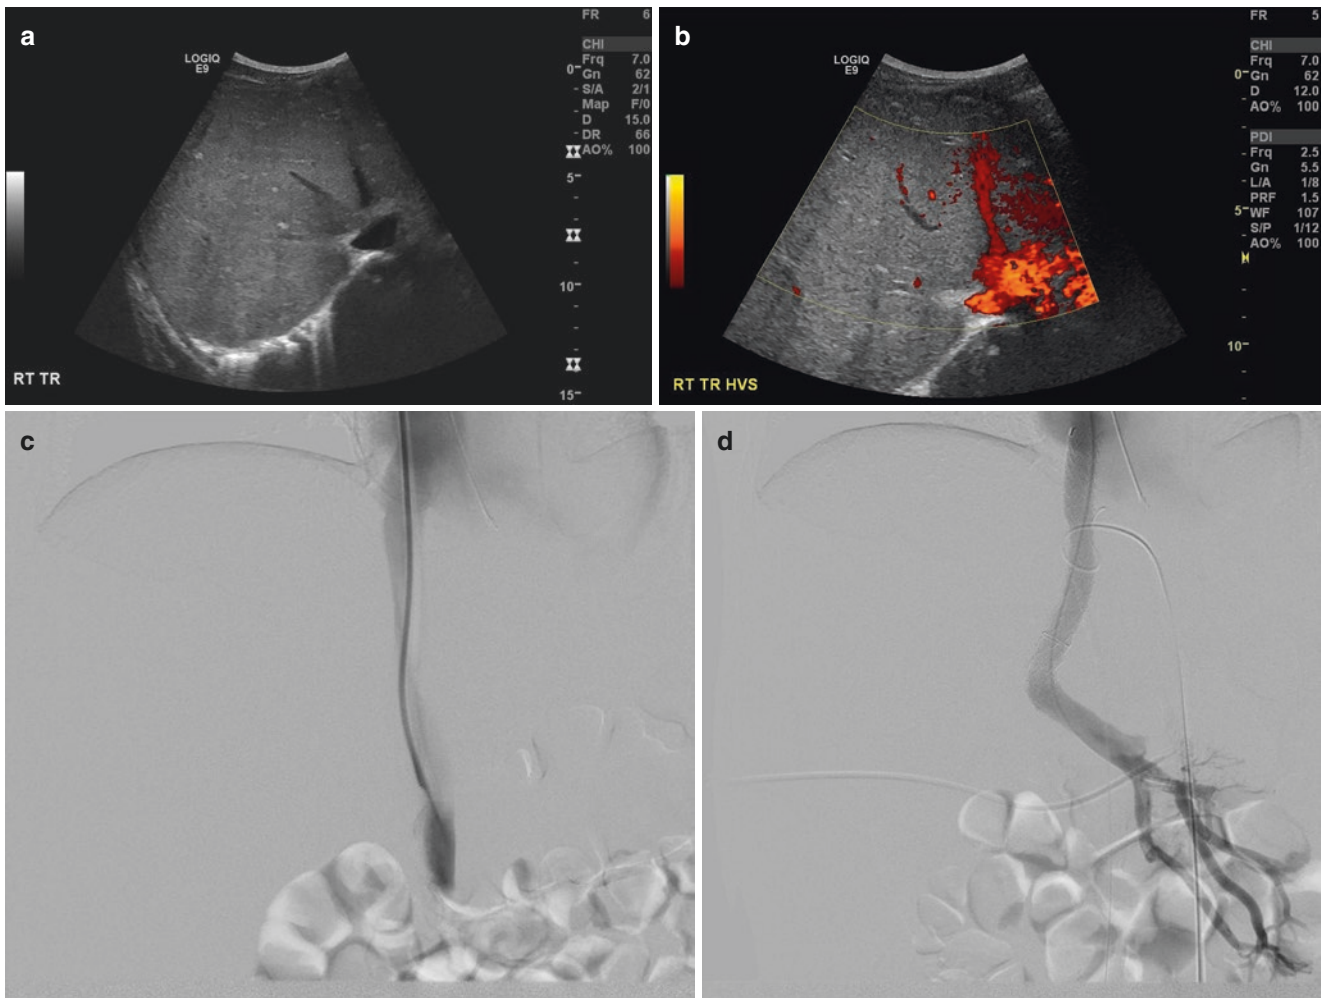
(a) Ultrasound of liver shows lack of visualization of right and middle hepatic vein with narrowing of left hepatic vein while (b) Doppler confirms lack of color flow in right and middle hepatic vein with reduced flow in left hepatic vein. (c) Liver venography reveals IVC
